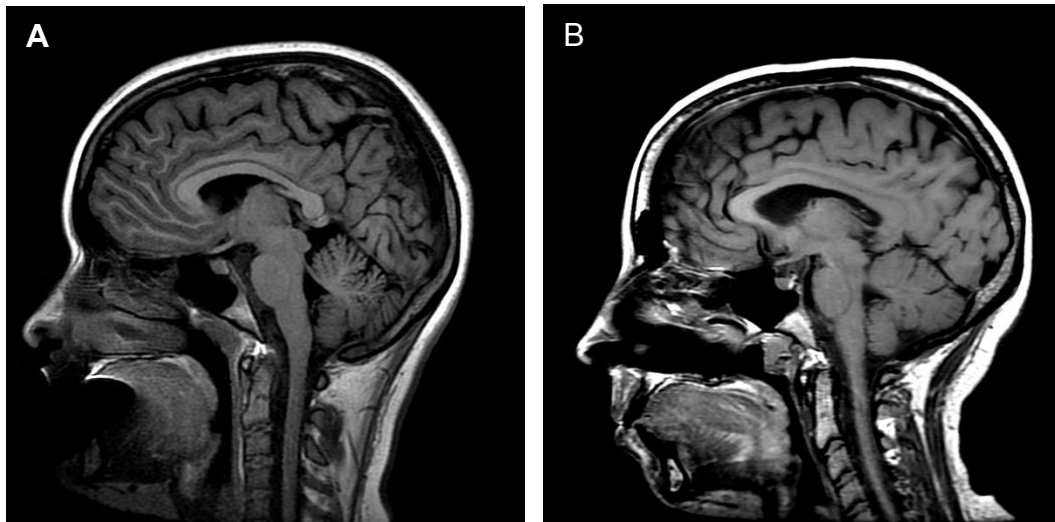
(A) Sagittal T1 FLAIR. Note the increased contrast between gray and white matter. (B) Sagittal fast/turbo spin echo. While both images demonstrate T1 weighting, T1 FLAIR often exhibits greater T1 contrast compared to the spin echo-based sequences.
